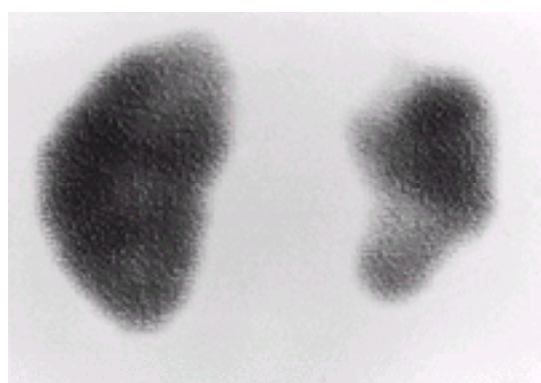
Technetium-99m DMSA scintigraphy (posterior view) demonstrating renal scarring. Split function: left = 64 per cent, right = 36 per cent.
